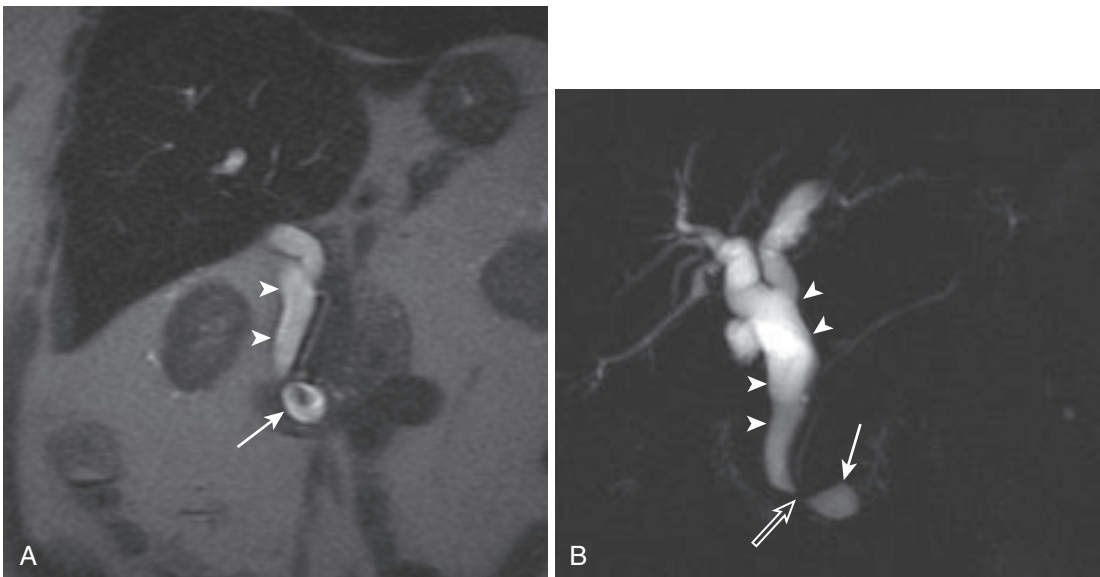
Type III choledochal cyst. An intraduodenal cystic lesion (*arrow*) is apparent on the MRCP (A) and coronal T2-weighted image (B), which is seen to be continuous with the common bile duct (*arrowheads*) consistent with a choledochoceles. Note the waisting at the level of the intraduodenal segment (*open arrow*).
